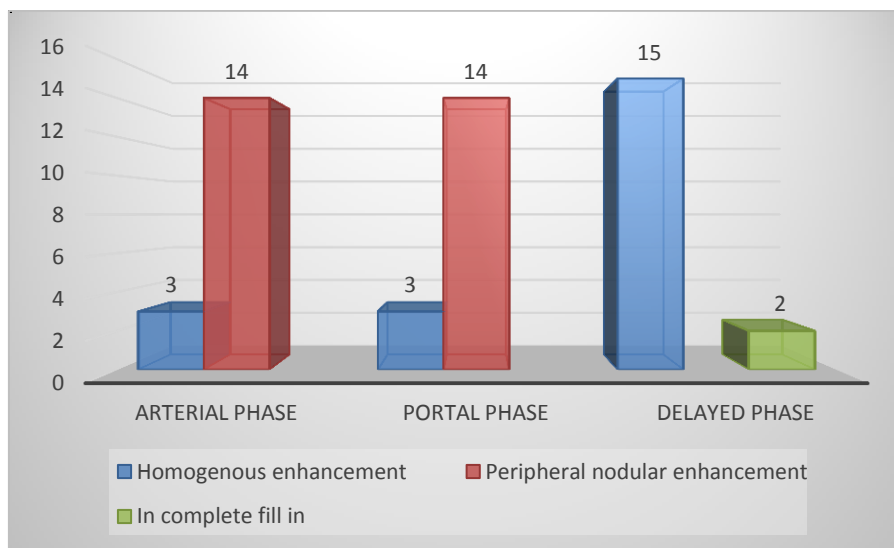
graph displays different patterns of enhancement of hemangiomas by dynamic MRI
